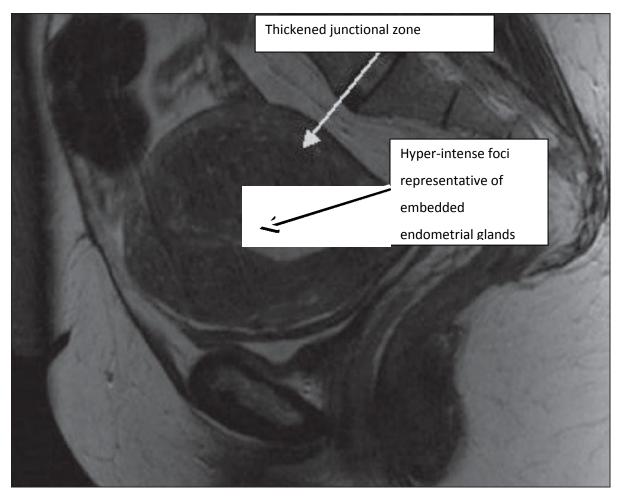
T2-weighted image of Adenomyosis
